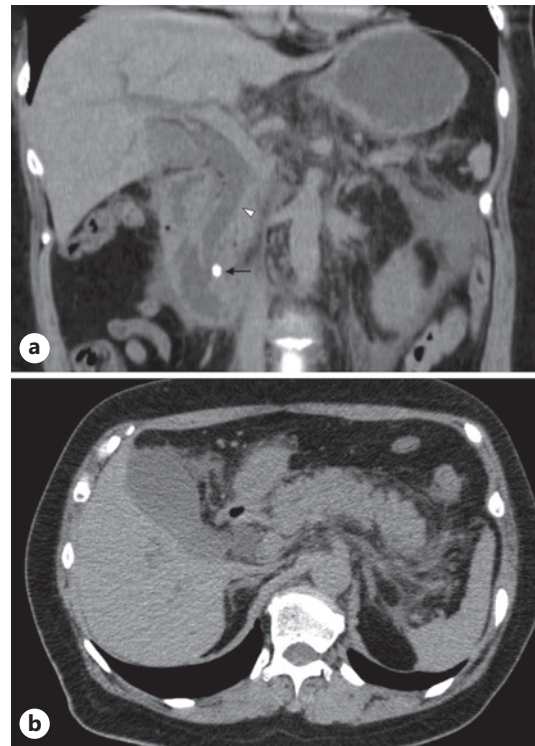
CT images on admission. a Coronal view. b Axial view. a A calcified stone (arrow) measuring 6 mm is observed in the papilla of Vater. Dilatation of the common bile duct is observed (arrowhead). b Diffuse swelling of the pancreas and peripancreatic inflammation are observed. No dilation of the MPD is observed.
